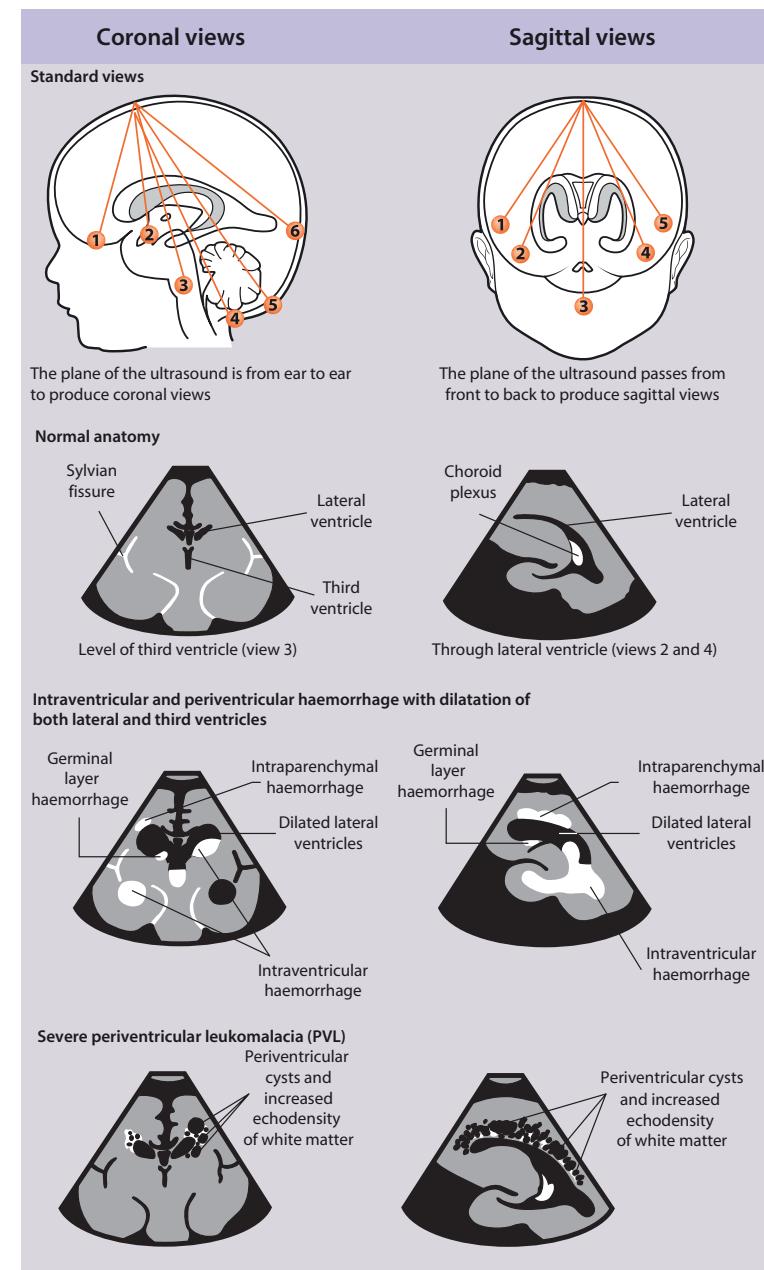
Cranial ultrasound in preterm infants.
